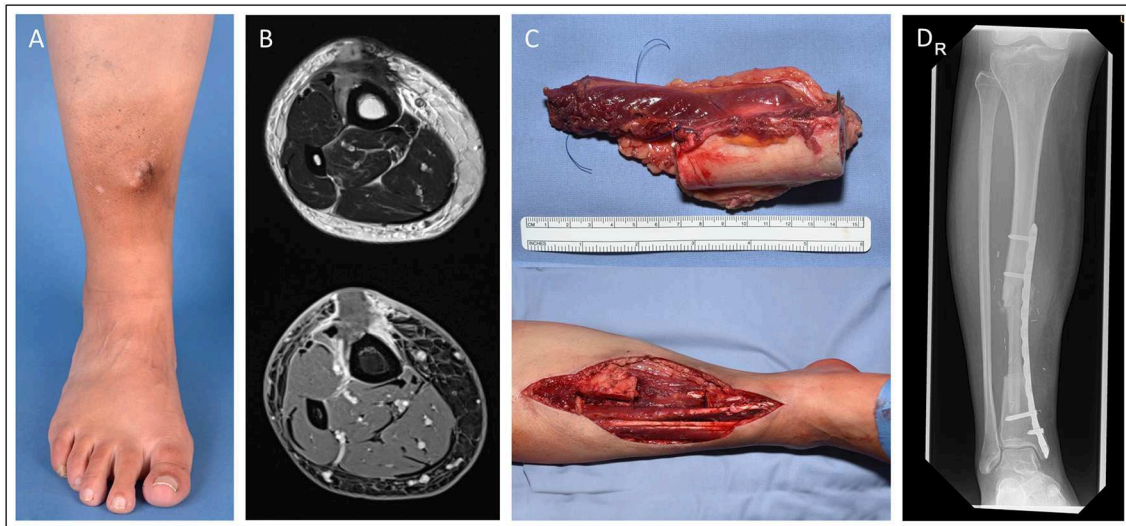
Patient presenting with a tibia-infiltrating leiomyosarcoma. Resulting primary bone defect was bridged by fibula-pro-tibia operation in an interdisciplinary approach. Pre-OP clinical (A) and MRI (B) presentation of the tumor. (C) Excised tumor tissue with affected tibia segment and lower leg during the resection. (D) Beginning tibialization of the fibula graft in the 8 months follow-up x-ray.
